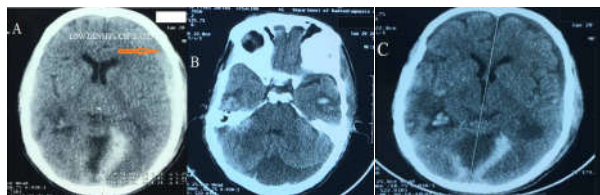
Case no.1 showing (A) initial CT head having acute SDH with midline shift and CSF band (arrow), (B) associated left temporal contusion & enlarged cisterna magna, (C) Repeat CT head after 12hours showing complete resolution of SDH
